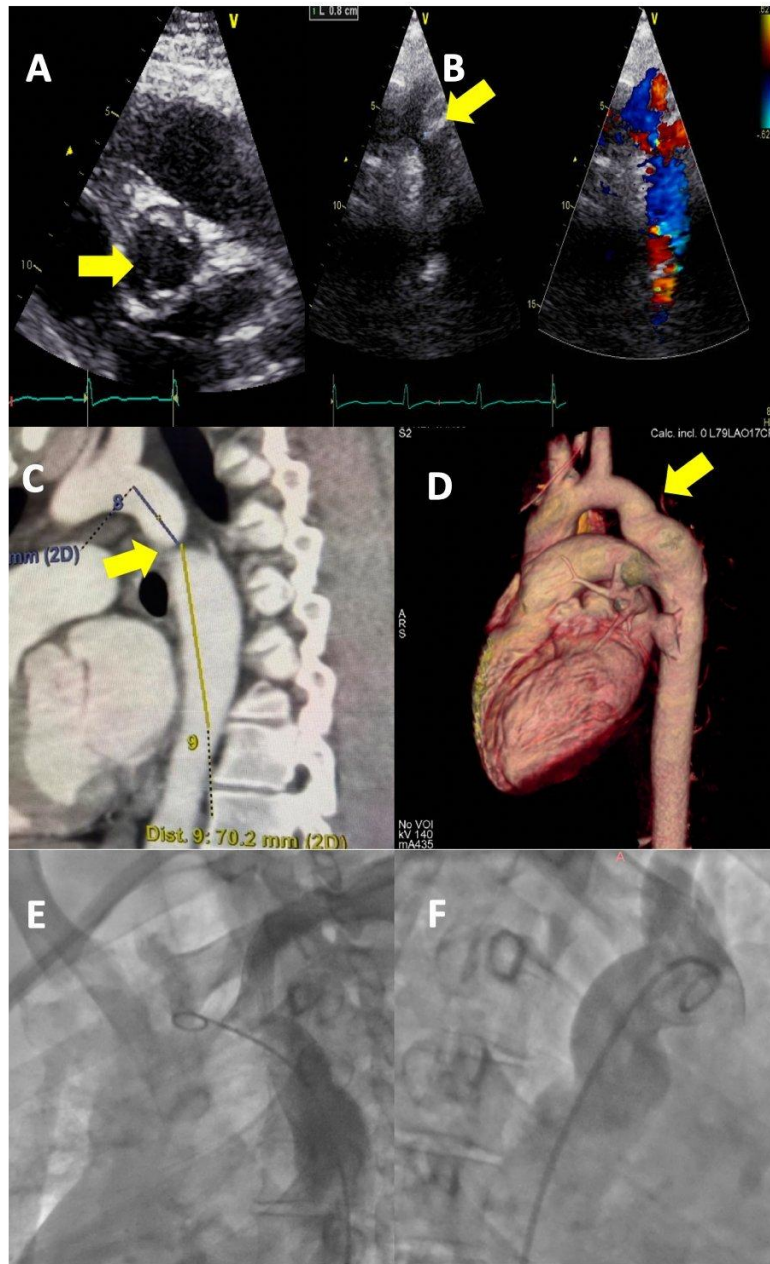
A) and B) Echocardiogram showing a bicuspid aortic valve with mild turbulence on color Doppler. C) Computed tomography angiography with measurements of the aortic arch and areas of narrowing. D) Three-dimensional reconstruction of the ascending aorta, aortic arch, and descending aorta. E) and F) Aortography showing a non-significant hemodynamic gradient.
